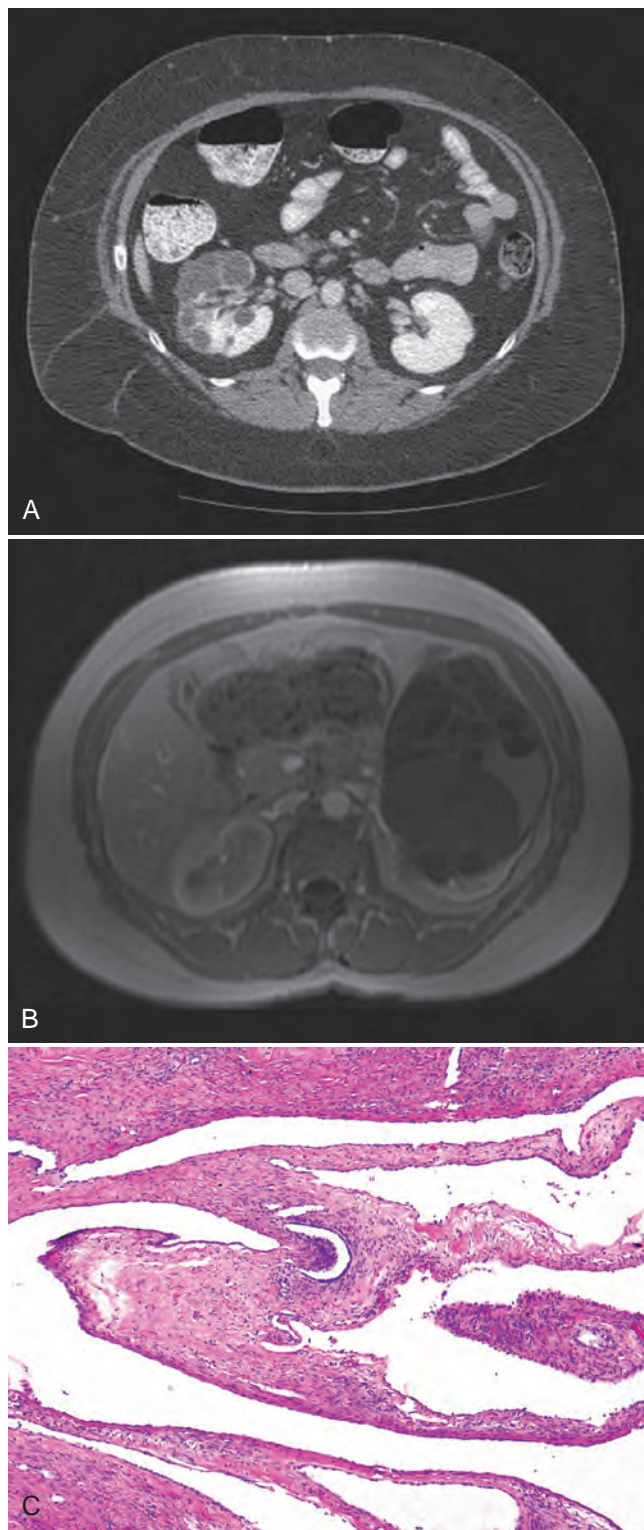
Cystic nephroma. Computed tomography (A) and magnetic resonance imaging (B) scans do not allow reliable distinction from cystic renal cell carcinoma or cystic Wilms tumor. C, The variably sized cystic spaces are lined by flattened epithelium (low magnification). (Copyright 2009, V. Margulis.)
